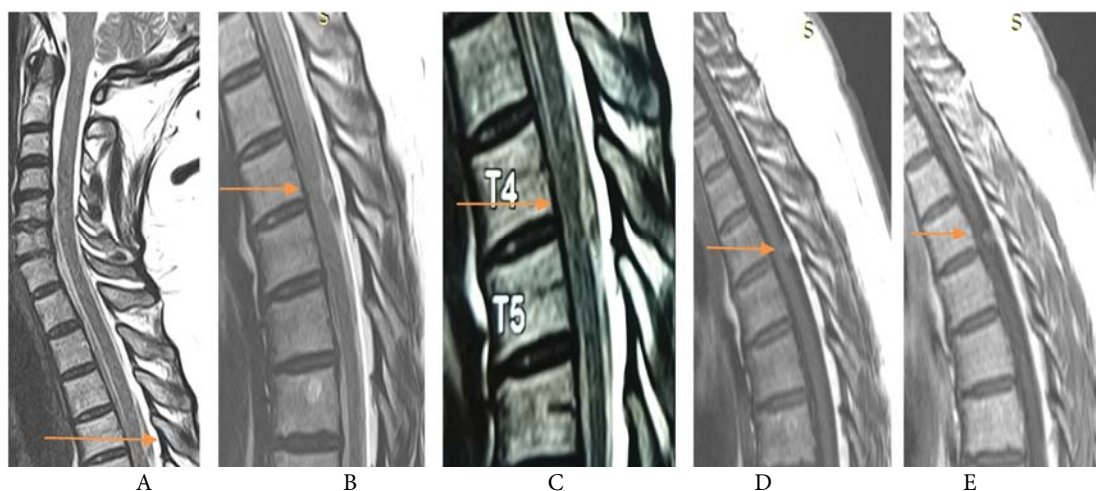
Sagittal T2 MRI: a cervical spine examination for bilateral brahial paresthesia - incidental discovery of a lesion in the thoracic spinal canal – an extramedullary, intradural lesion, T7 vertebral hemangioma, B & C sagittal T2, D sagittal T1 after Gadolinium injection – with heterogenous signal in T2w and E sagittal T1 w (calcifications possible) + poor enhancement of the lesion
